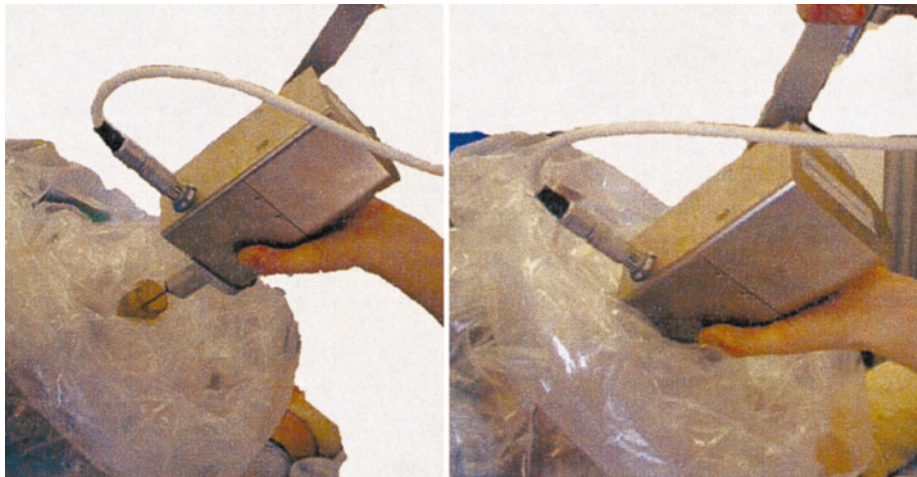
The X-ray source is being inserted into the applicator.
